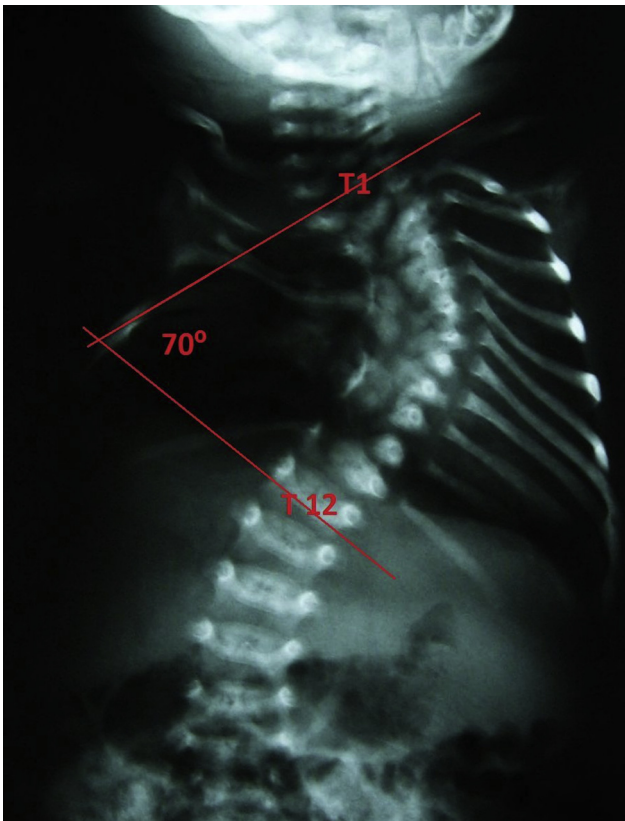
The first X-ray at the age of 3 weeks: thoracic T1–T12 scoliosis with a  $70^\circ$  curve and multiple rib agenesis, hypoplasia, and fusions.
